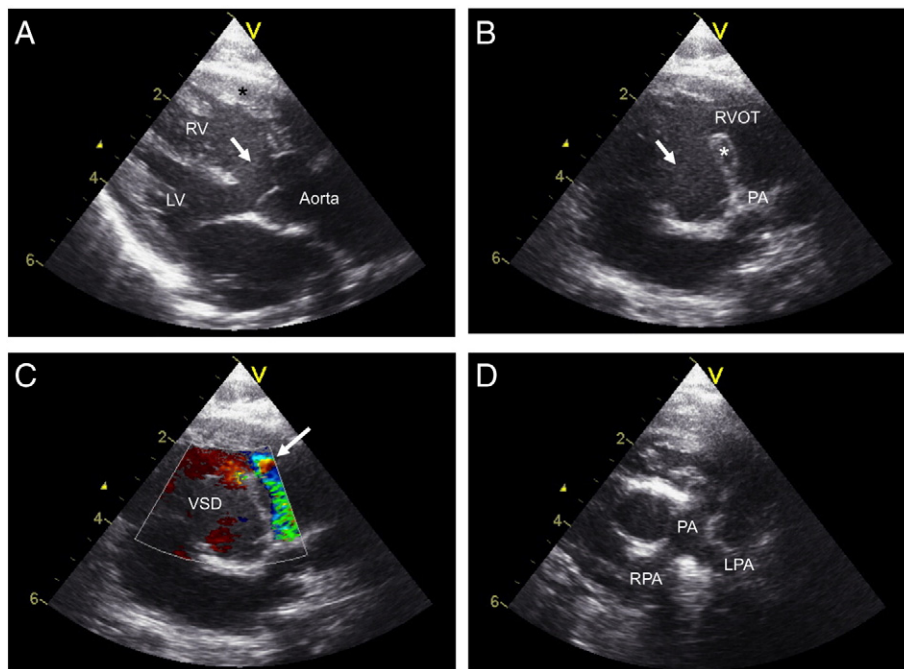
Echocardiographic views of the morphological features of tetralogy of Fallot. (A) Parasternal long-axis view showing the overriding aorta and the ventricular septal defect (VSD, arrow). Right ventricular hypertrophy can also be appreciated in this image (*). (B) The anatomy of the right ventricular outflow tract (RVOT). The essence of TOF is an antero-superior deviation of the infundibular septum (*), giving rise to the VSD (arrow) and narrowing of the RVOT. (C) Parasternal short-axis view. Color Doppler image visualizing the subpulmonary obstruction (arrow). (D) View of the main pulmonary artery (PA) and its branches, showing mild hypoplasia of the pulmonary arteries. LPA = left pulmonary artery; LV = left ventricle; RPA = right pulmonary artery; RV = right ventricle.
